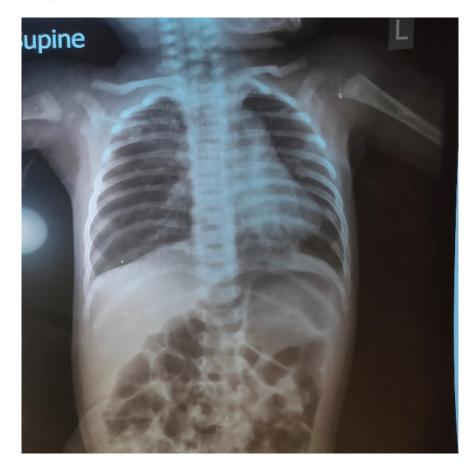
X-ray chest Postero-anterior (PA) view at 2 months of age reported as right upper zone pneumonia.
